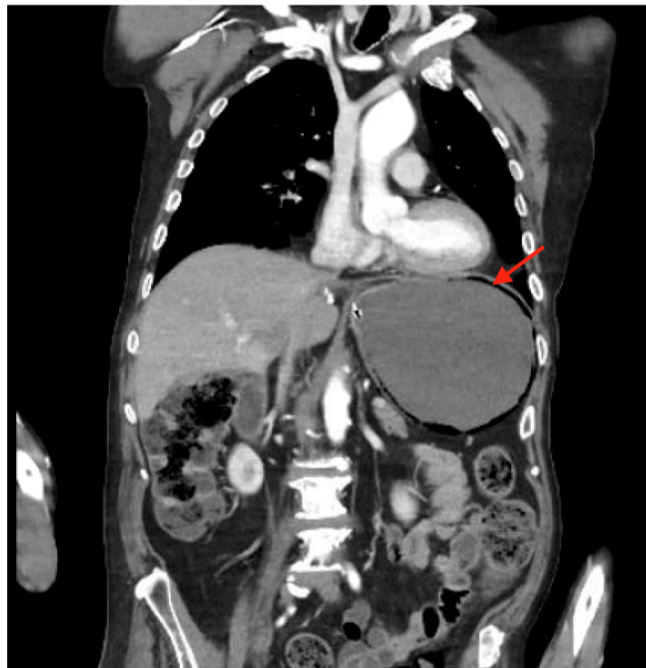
Contrast-enhanced CT with intravenous contrast. Coronal section demonstrating diffuse gastric mural gas, most prominent in the cardia and antrum (arrow).
